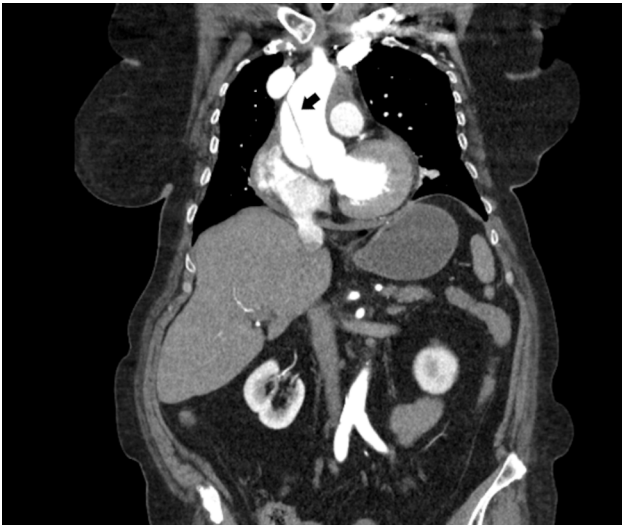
Contrast-enhanced CT scan of the thoracic vasculature in the frontal projection: the ascending aorta is dilated at the dissection site, with intimal delamination (black arrow) and uniform enhancement of both true and false vascular lumina
